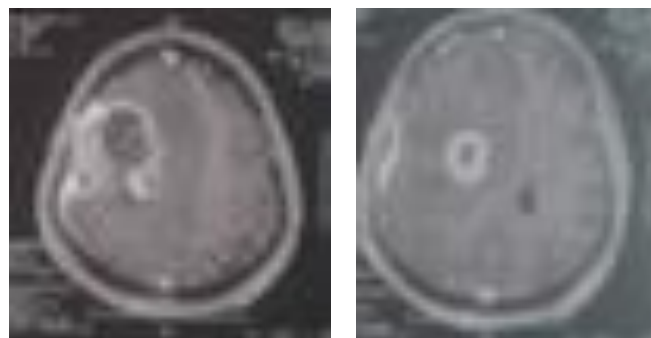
Brain MRI showing the tumor.
